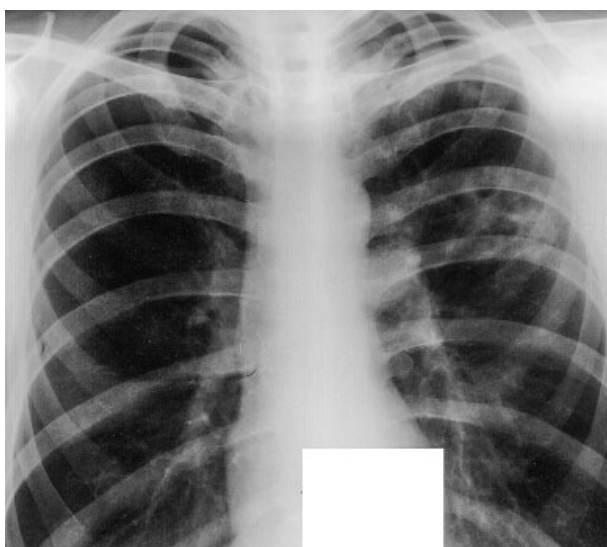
Chest X-ray from 07.07.2023 (after 2 months)
